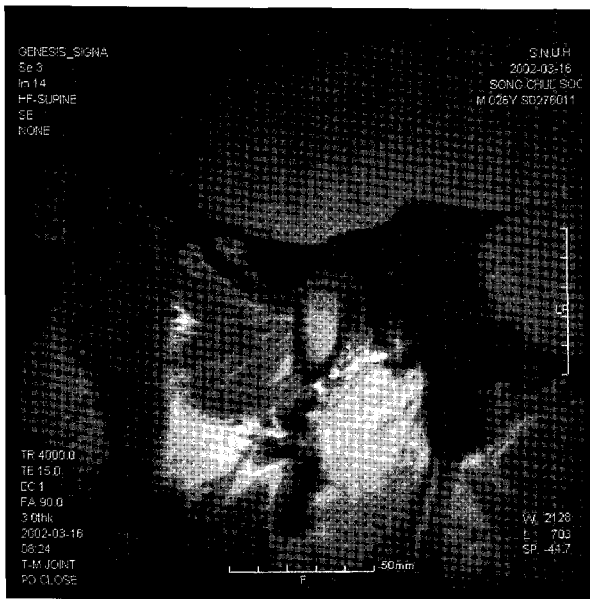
MRI analysis – normal (left : closed state, right : open state).
